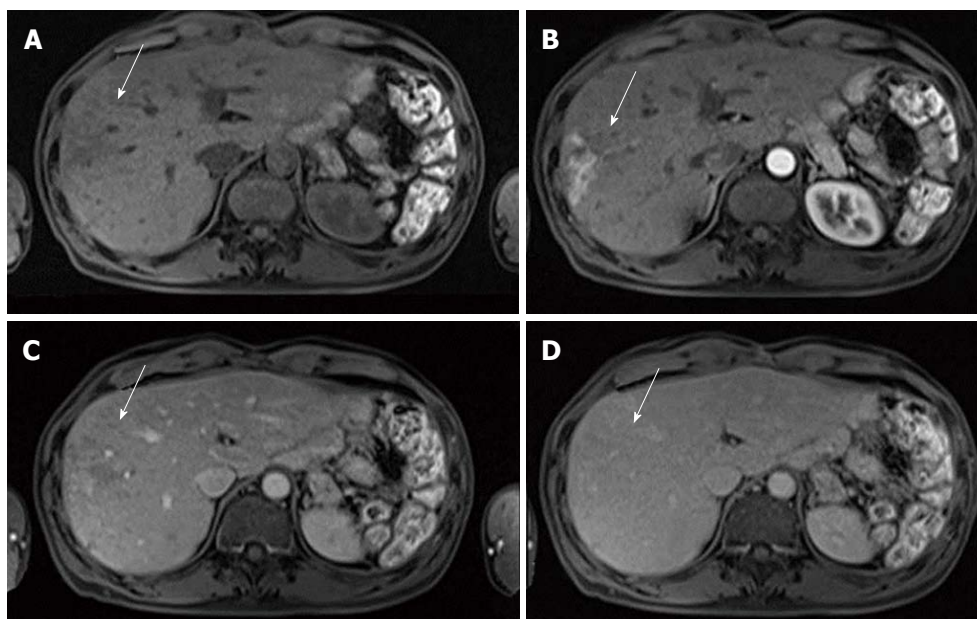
Dynamic magnetic resonance imaging demonstrated an arterial enhance mass like lesion as same as computed tomography scan. A: Pre-enhanced image; B: Arterial phase image; C: Portal phase image; D: delayed phase image.
